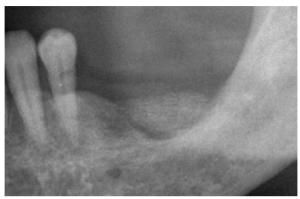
Radiograph showing the block placed in the defect area of the mandible. Note that the block was not fixed to the recipient site with screws.
